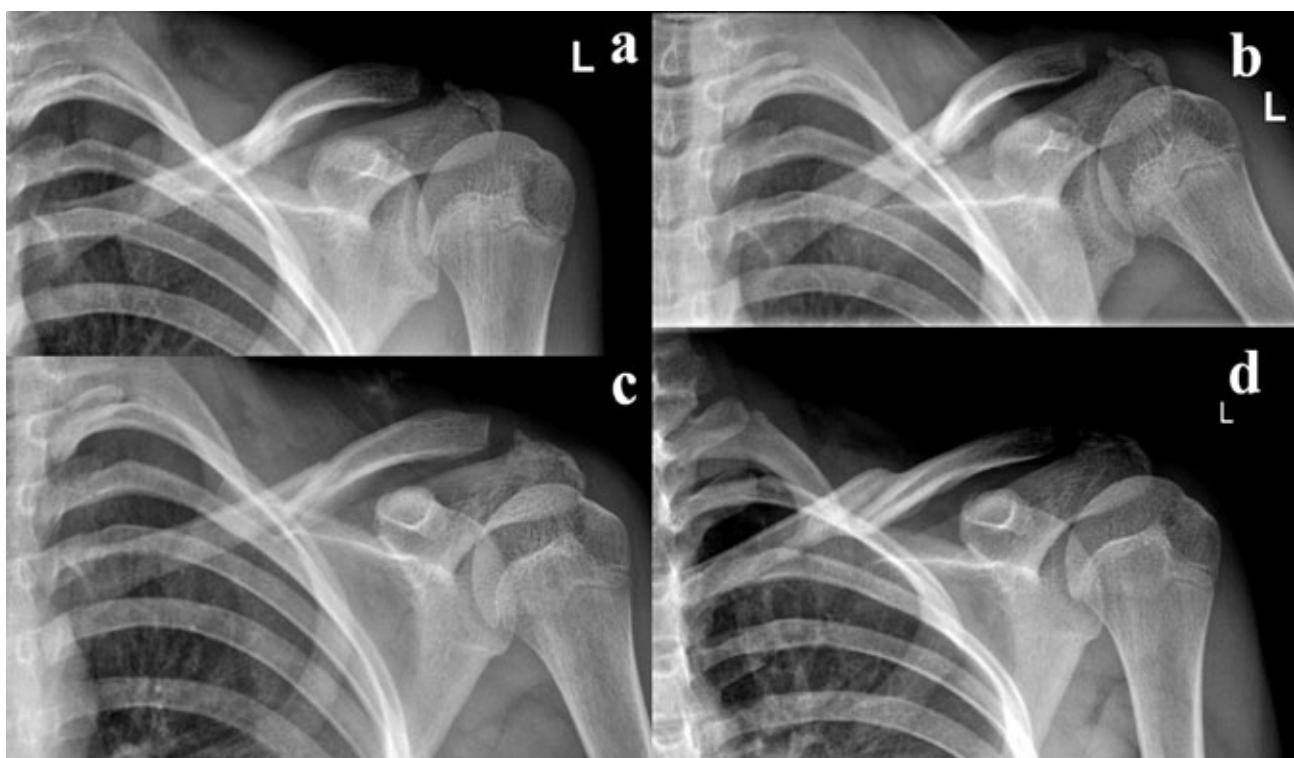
Plain radiograph in AP view: 1a – initial traumatic X-ray, 1b – after figure 8 bandage, 1c – follow up X-ray scan during diagnosis of the brachial deep venous thrombosis, 1d – after fracture healing.
